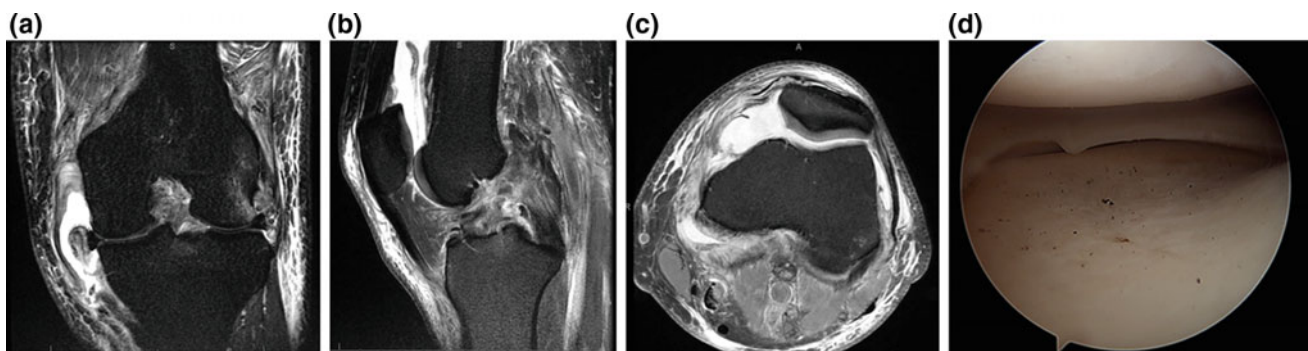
Coronal (a), sagittal (b), and axial (c) MRI images of a KDIIIM with a torn MPFL requiring reconstruction of ACL, PCL, MCL, and MPFL. Notice the evidence of partial lateral corner injury that was structurally intact on EUA, stress radiographs, and stress arthroscopy (d)
